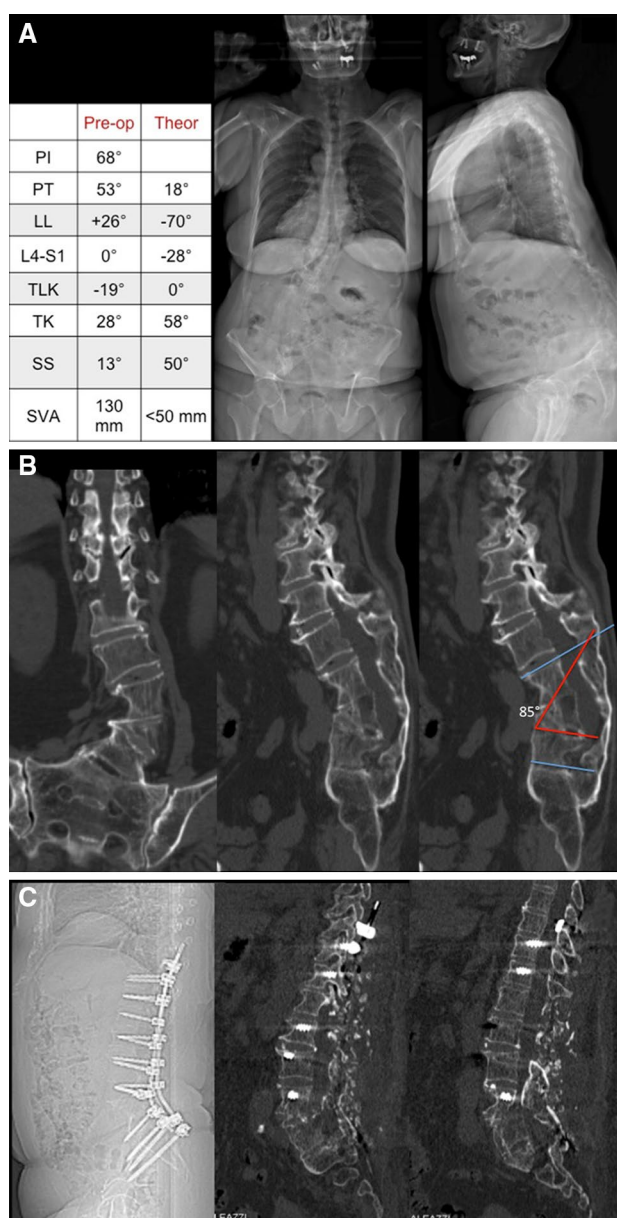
Hypercomplex PSO case. The patient is a 70 year-old lady with L2-sacrum posterior fusion for congenital deformity 30 years earlier. She presents with progressive, unbearable back pain and difficulty to maintain the standing position. a EOS films and table with spinopelvic parameters. b Coronal and sagittal CT scan showing the fusion mass and the complex coronal and sagittal deformity. The lumbar sagittal alignment is shown with blue lines. The planned osteotomy of 85° at a single point (including 2 consecutive pairs of pedicles) is shown in red. c CT scan showing the correction with satisfactory alignment
